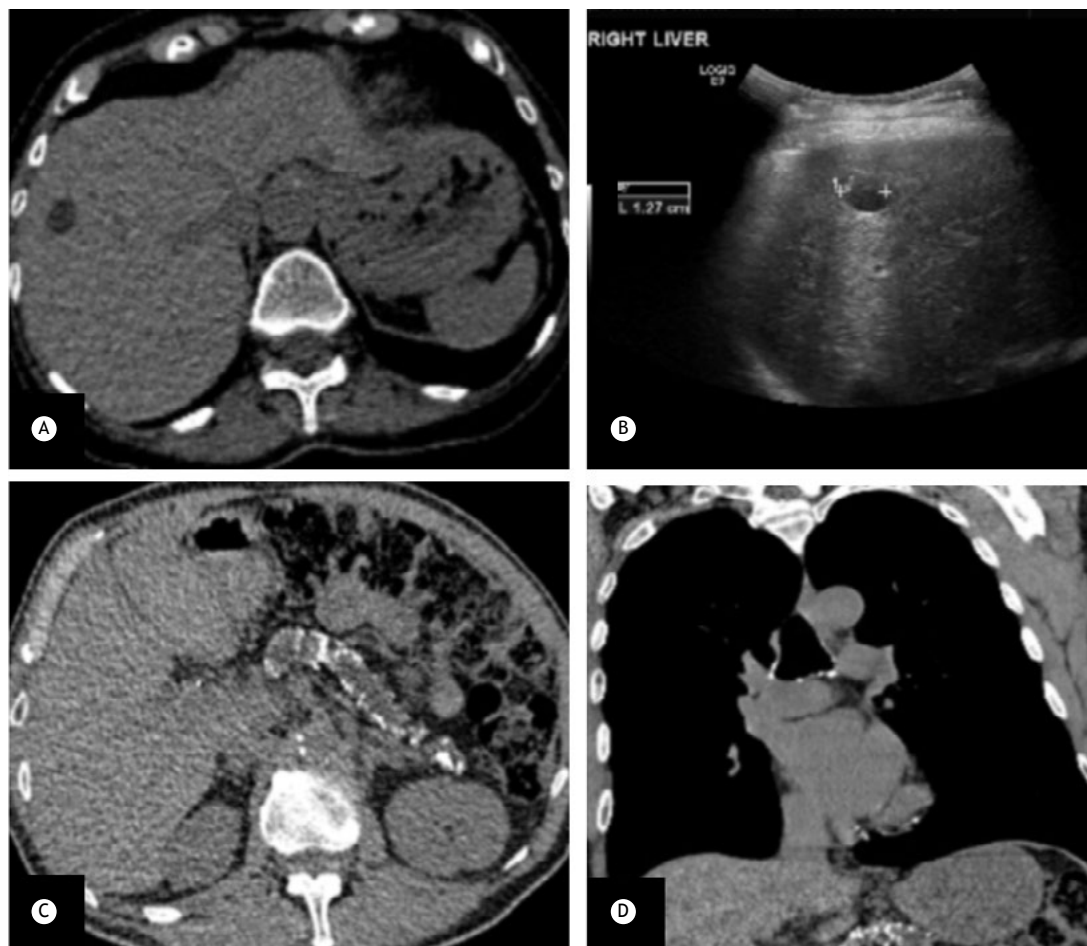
Incidental abdominal findings. In A, axial image showing a focal hypodense liver lesion of 13 mm. Density was found to be inaccurately measured by low-dose CT. This was mentioned in the report, and the medical team decided to request an ultrasound scan. In B, ultrasound scan showing the benign features of a cyst. In C and D, axial and sagittal images of a different patient, showing another incidental finding, i.e., several coarse calcifications in the atrophic pancreatic parenchyma, with dilated pancreatic duct, in keeping with chronic pancreatitis. Pancreatic disease is not commonly depicted on low-dose CT scans for lung cancer screening, because low-dose CT has reduced sensitivity for pancreatic lesions and because the usual field of view does not cover the pancreas.
